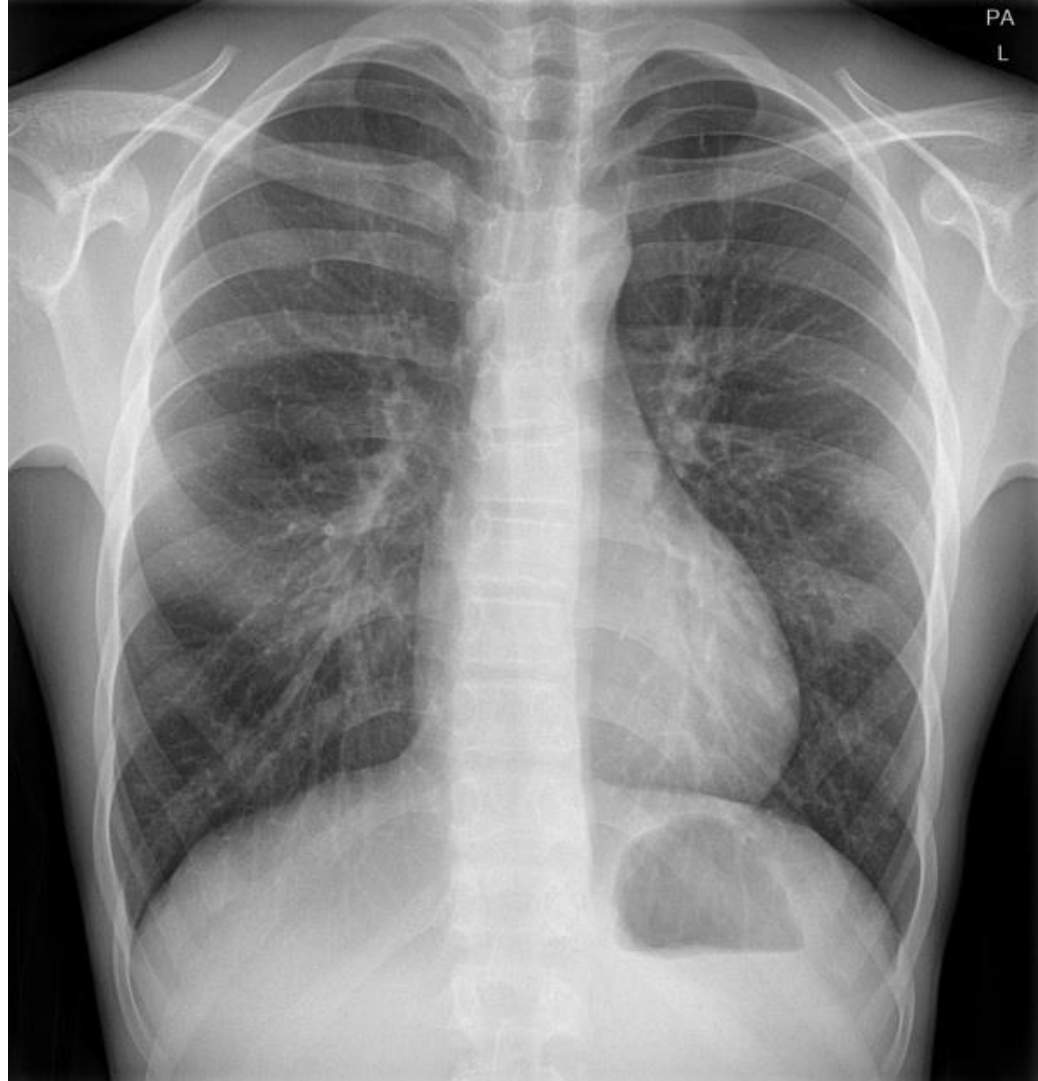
Normal chest x-ray. Case courtesy of Dr. Derek Smith, Radiopaedia.org, rID: 62093 ²⁰
